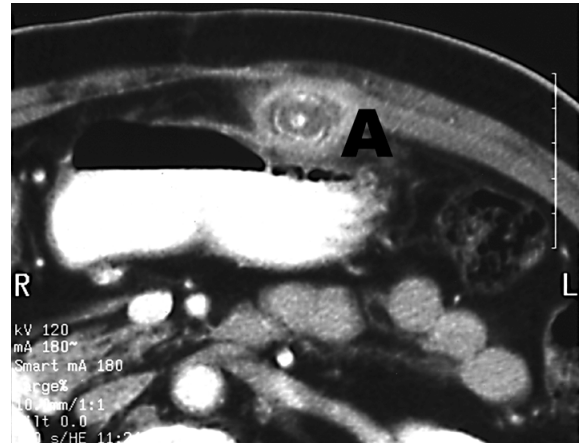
CT scan of the upper abdomen demonstrating the Gallstone Granuloma (A).
